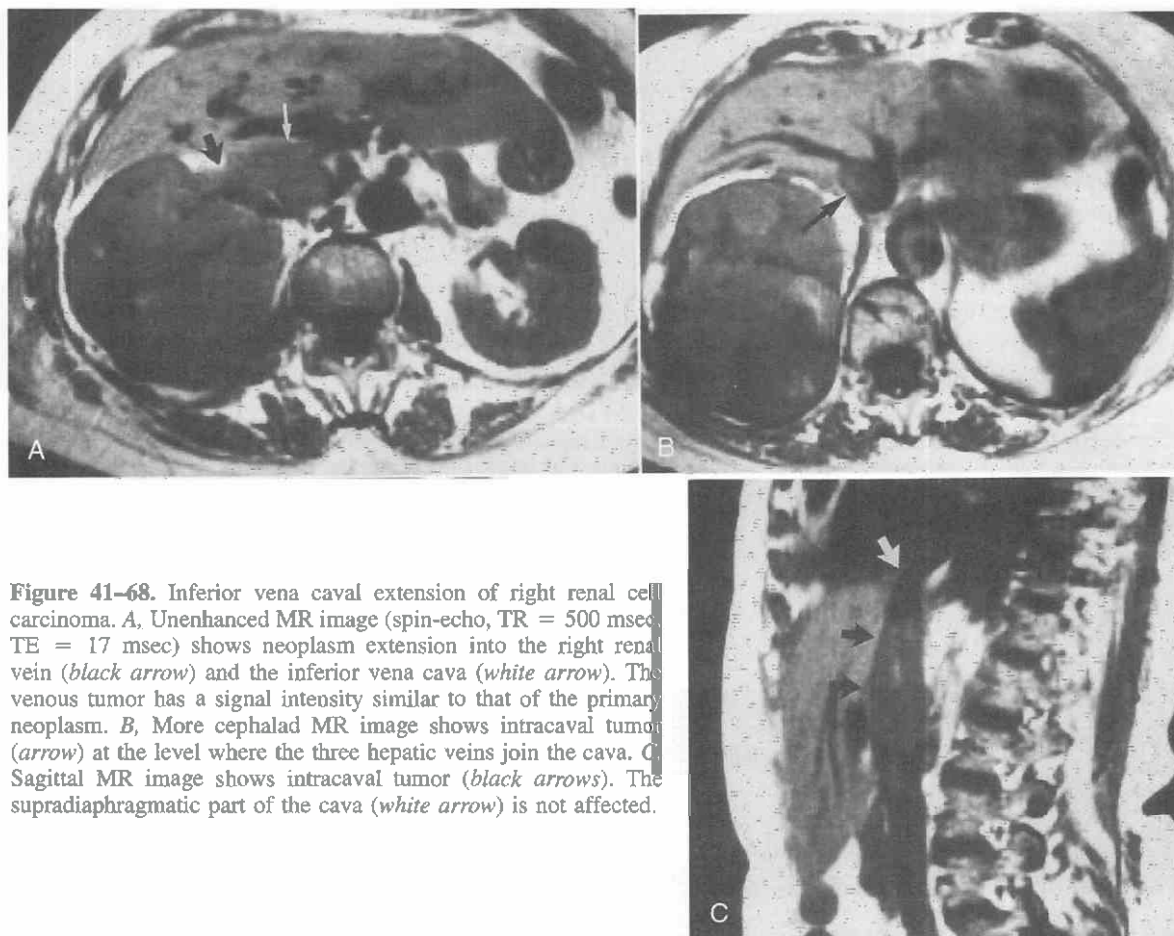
Inferior vena caval extension of right renal cell carcinoma. A, Unenhanced MR image (spin-echo, TR = 500 msec, TE = 17 msec) shows neoplasm extension into the right renal vein (black arrow) and the inferior vena cava (white arrow). The venous tumor has a signal intensity similar to that of the primary neoplasm. B, More cephalad MR image shows intracaval tumor (arrow) at the level where the three hepatic veins join the cava. C, Sagittal MR image shows intracaval tumor (black arrows). The supradiaphragmatic part of the cava (white arrow) is not affected.
